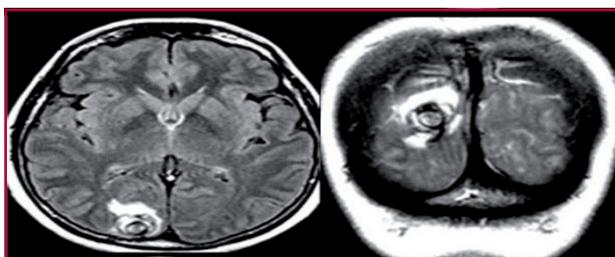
Brain MRI showing cortical and subcortical lesions.
